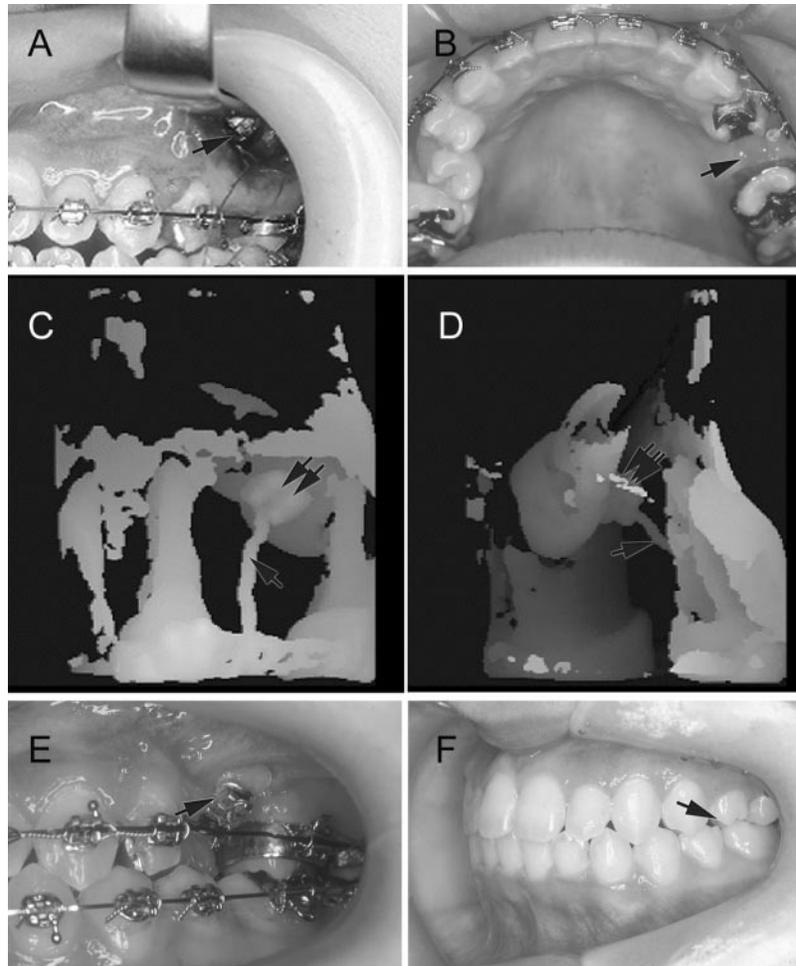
Case 2: (A) The surgical fenestration and retraction of impacted tooth. Single arrows indicate impacted tooth. (B) The impacted tooth was covered by gingival tissue. Single arrows indicate covered gingival tissue at impacted premolar. (C,D) 3D computed tomography (CT) images. Single arrows indicate ligature wire, and double arrows indicate orthodontic brackets, which are bonded on the impacted tooth surface. (E) The left premolar tooth erupted after one year and six months; single arrows indicate the left second premolar. (F) After orthodontic treatment. Single arrows indicate the left second premolar.
